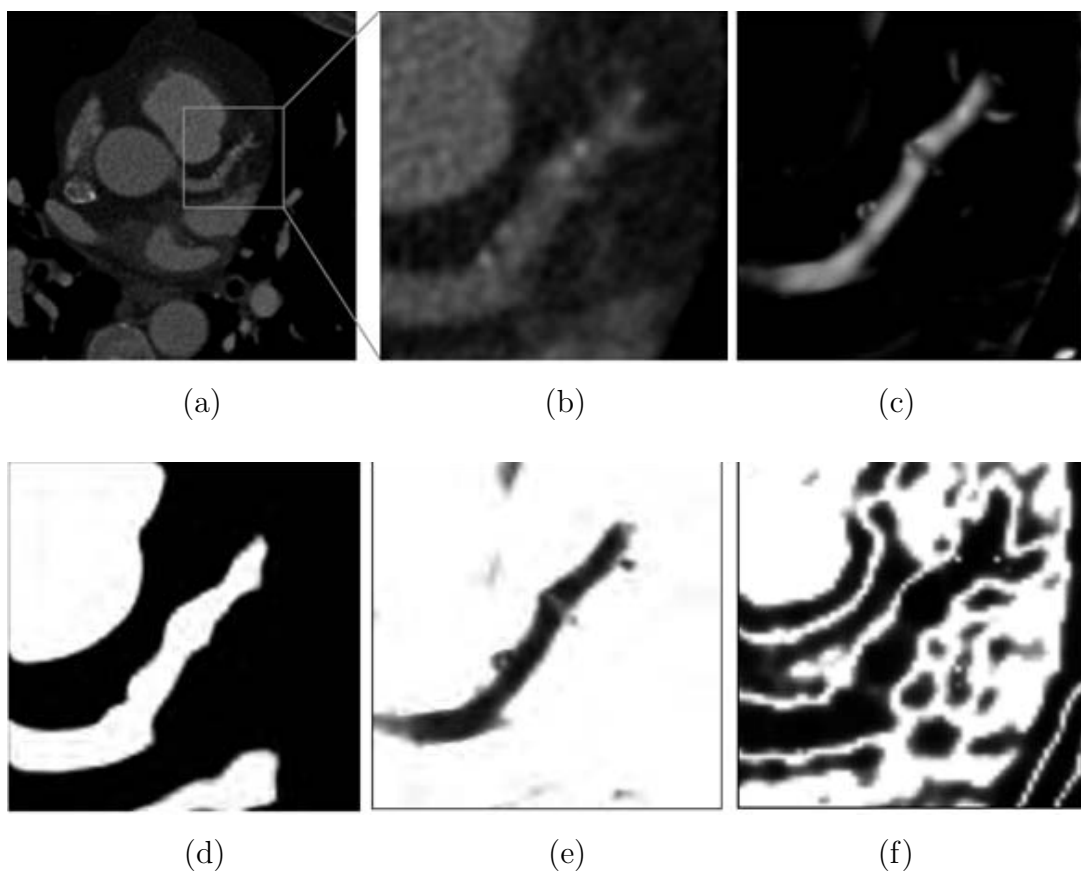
Examples of CTA image and its corresponding cost images [154]. (a): CTA image; (b): Region of interest; (c): Vesselness; (d): Post-processed intensity image; (e): Cost image combining vesselness and intensity measures; (f): Region statistics cost image.
